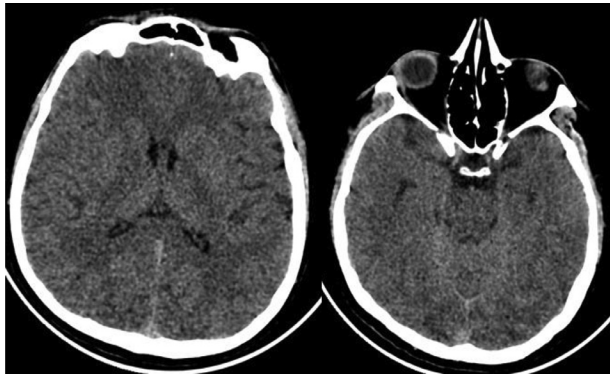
Initial non-contrast axial CT brain images (normal)
